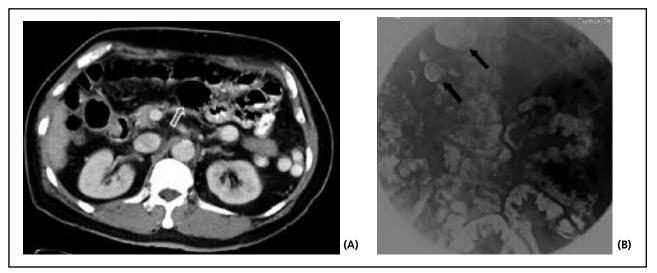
(A) Axial CT demonstrated diverticula (red arrow) in the proximal jejunum. (B) Prone abdomen radiograph from small bowel follow through demonstrated retained contrast in the outpouchings (black arrow) from jejunum, which was suggestive of diverticula.
